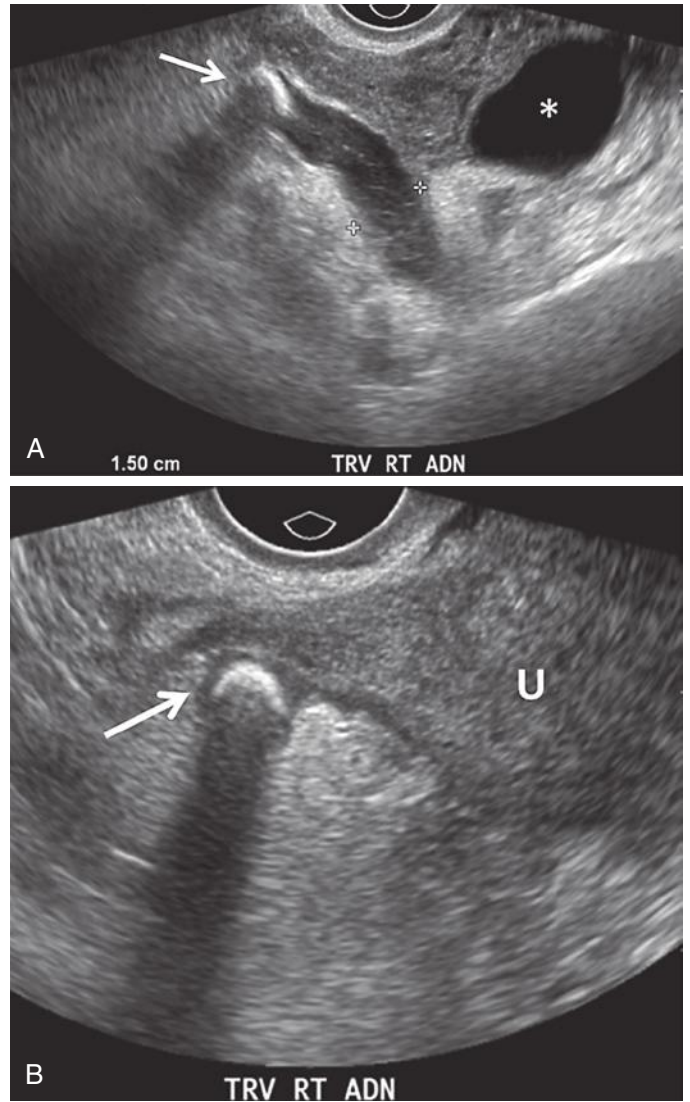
Acute appendicitis. A 37-year-old woman presented with pelvic pain and chills for 2 days. Transvaginal sonographic images of right adnexa (A and B) revealed a tender, fluid-filled tubular structure (*calipers*) measuring 1.5 cm in diameter lateral to the right ovary. Also shown is a sharply marginated echogenic round structure (*arrow*) with dense acoustic shadowing, consistent with appendicolith. Also note increased echogenicity of the adjacent pelvic fat, a nonspecific finding indicative of inflammation or infection. *Asterisk*, right ovarian cyst; *U*, uterus.
